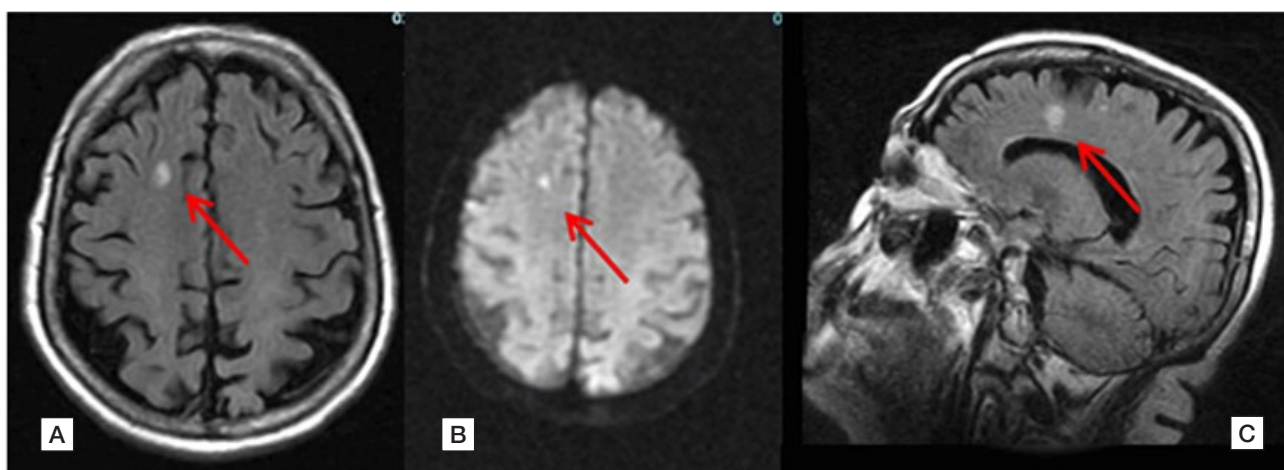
MRI findings: [A] - Axial T2-weighted FLAIR image showing a hyperintense lesion in the right frontal subcortical white matter (red arrow); [B] - Axial diffusion-weighted imaging (DWI) demonstrating restricted diffusion in the same region (red arrow), consistent with an acute ischemic lesion; [C] -Sagittal T2-weighted FLAIR image revealing a hyperintense lesion in the right frontal subcortical white matter (red arrow).
